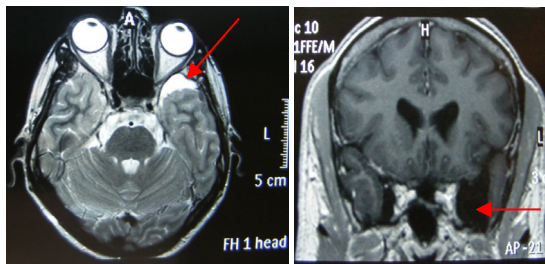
MRI- Gallasi I left temporal pole ACs-observational treatment
